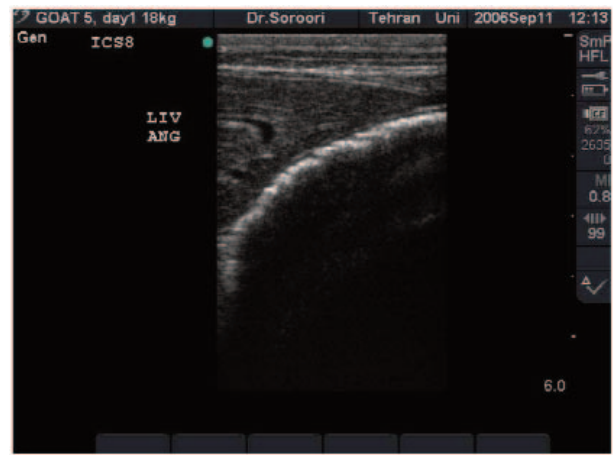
Ultrasonogram of the visceral angle of the liver. Transducer was placed in the 8th ICS. LIV ANG: Liver angle.
